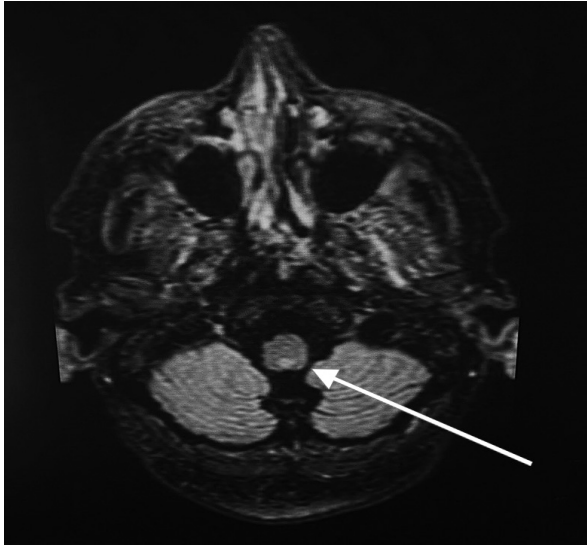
Case 1. MRI scan showing a T2-hyperintense lesion in the medulla oblongata manifesting as area postrema syndrome
